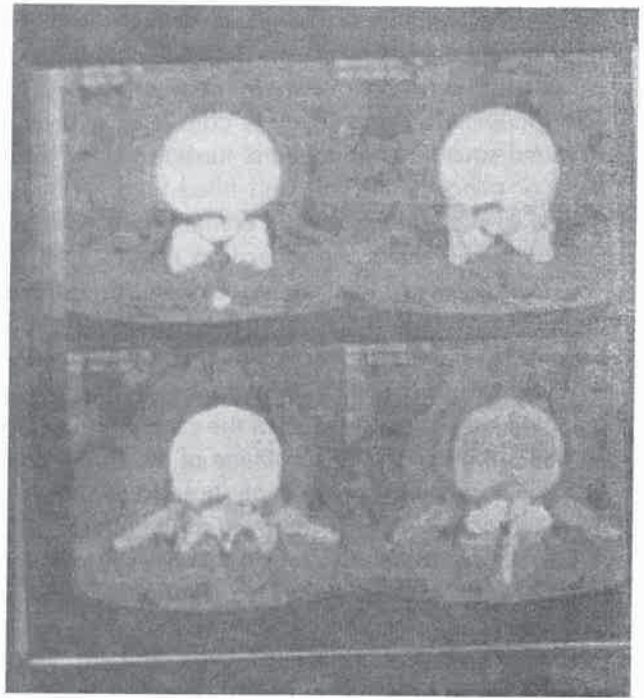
Computed tomographic scan shows an intramedullary tumor containing several high - density areas.
